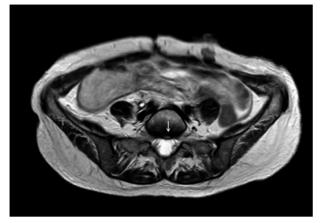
Axial view of MRI (T2 sequence) showing at the L5-S1 disc (arrow)
